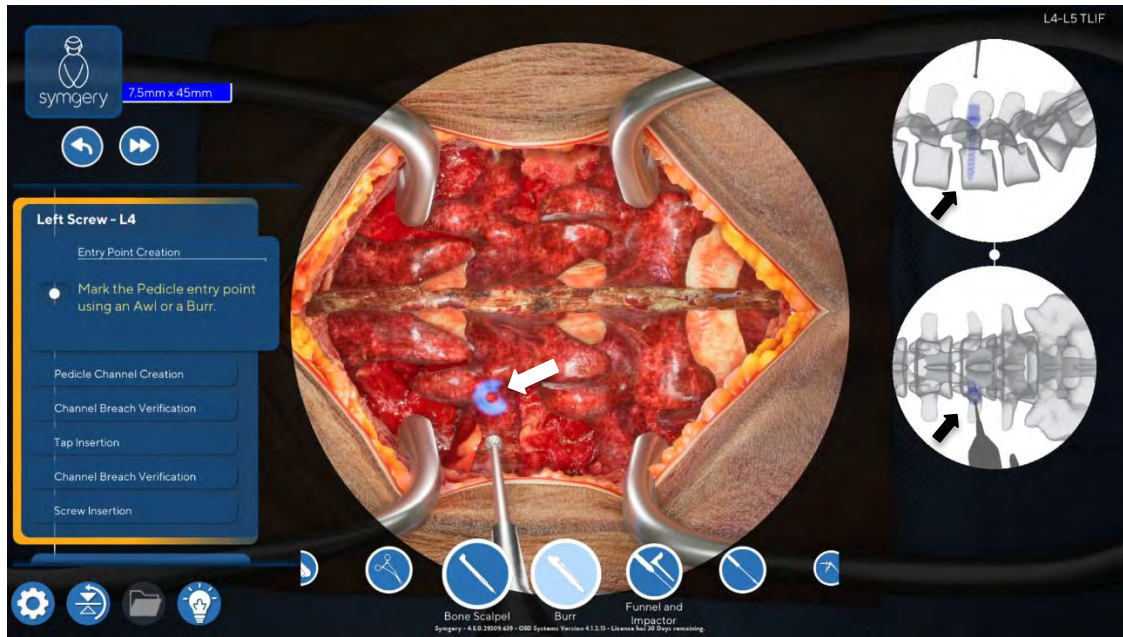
Example of the entry point guide in the OR and the ideal Screw displayed in the X-ray in TLIF Technique.
